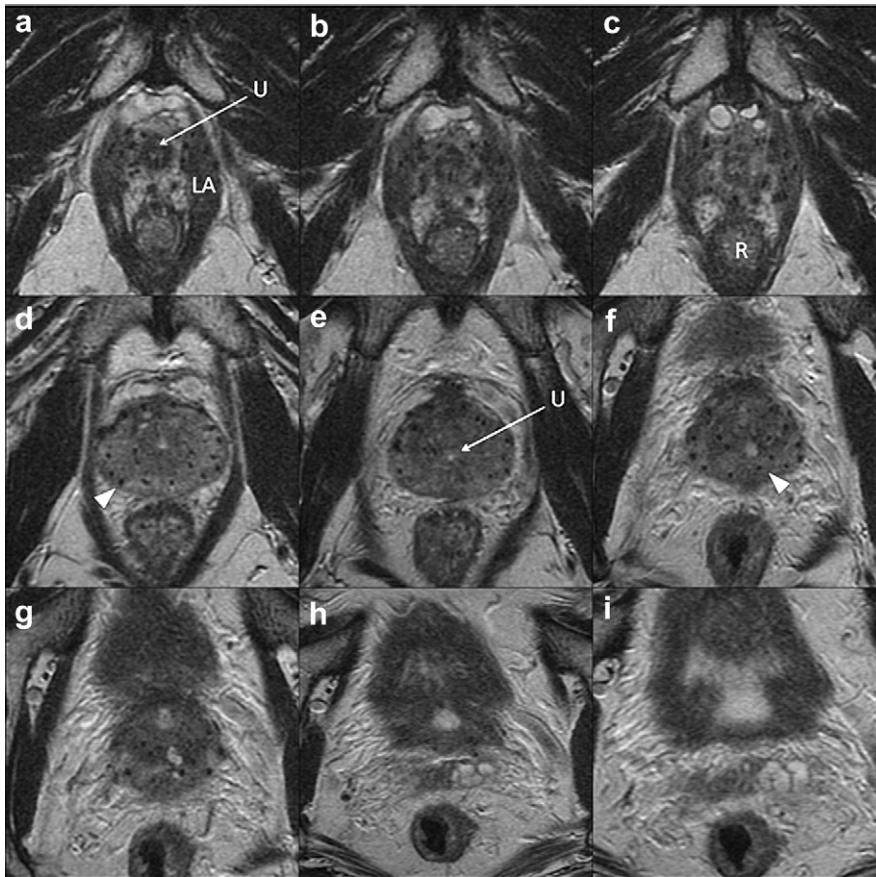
Magnetic resonance image series of the prostate (repetition time [TR] = 4500 msec, echo time [TE] = 90 msec, echo train length [ETL] = 10, bandwidth [BW] = 80 Hz/pixel). Image (b) represents the most inferior slice, where prostate is visible. Images (d–f) are taken through the midgland. Image (h) represents the most superior slice, where prostate is visible. Example seed voids are demonstrated with the white arrowheads. LA = levator ani muscle; U = urethra; R = rectum.
